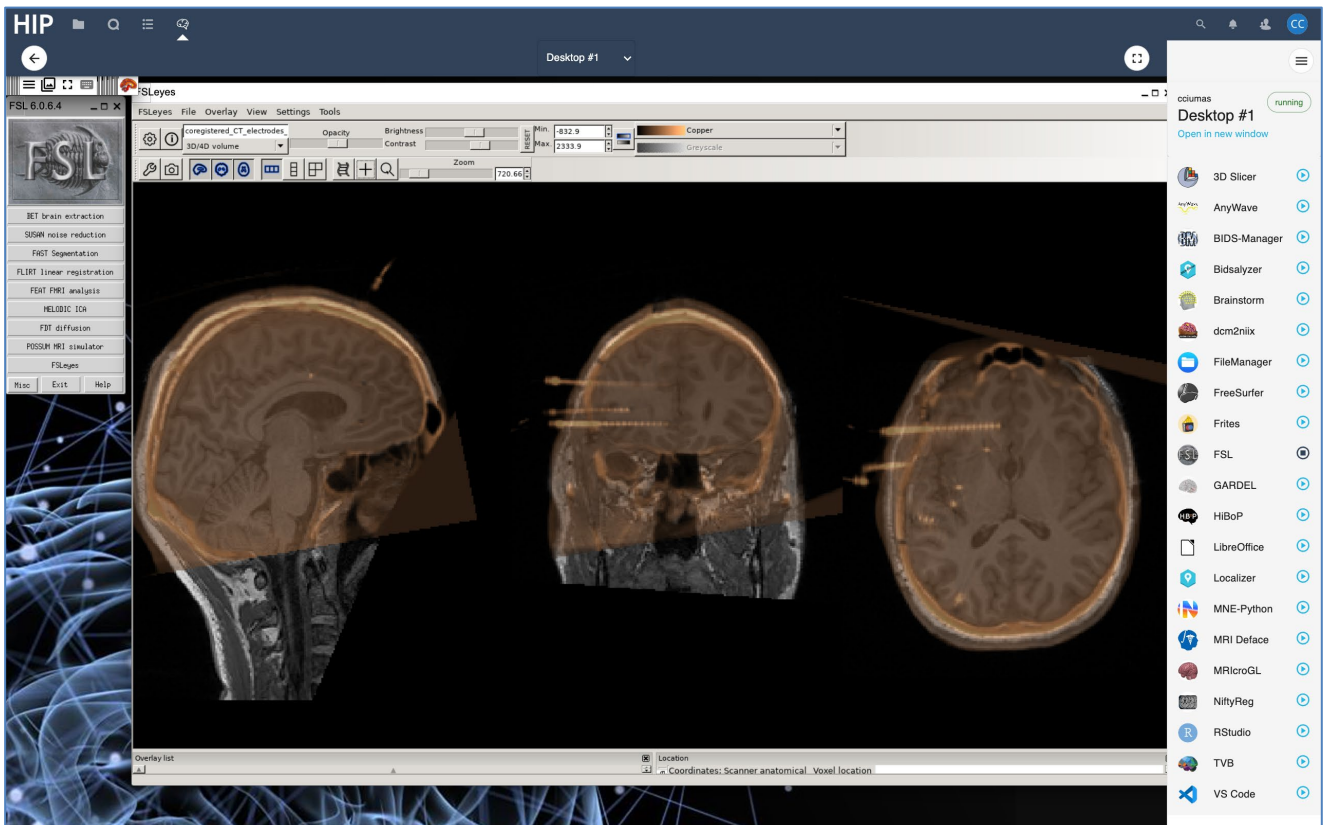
Co-registered CT with implanted electrodes & the T1 image - visualisation with FSL
